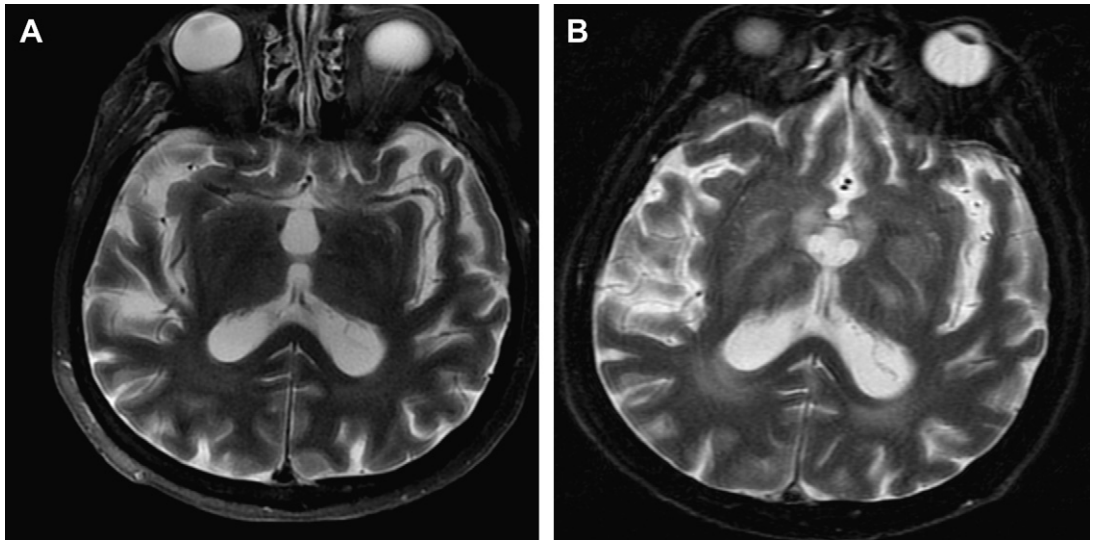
West Nile virus. (A) T2-weighted images are initially unremarkable other than for age-related volume loss. (B) T2-weighted image acquired 2 months later demonstrates abnormal T2 signal involving the thalami and imaged portions of the inferior basal ganglia bilaterally.
